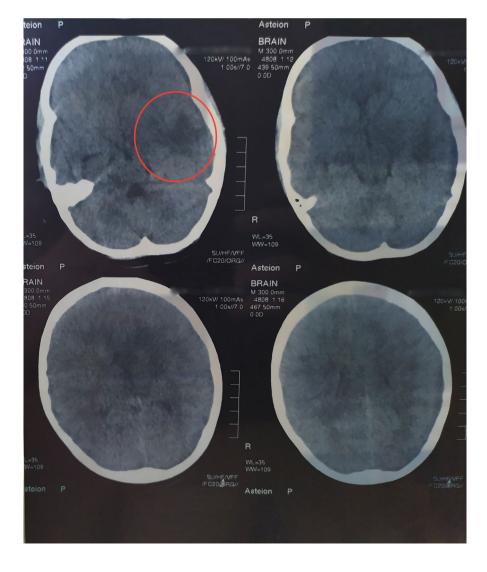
Axial CT image shows cerebral edema with low-density area (circle)
